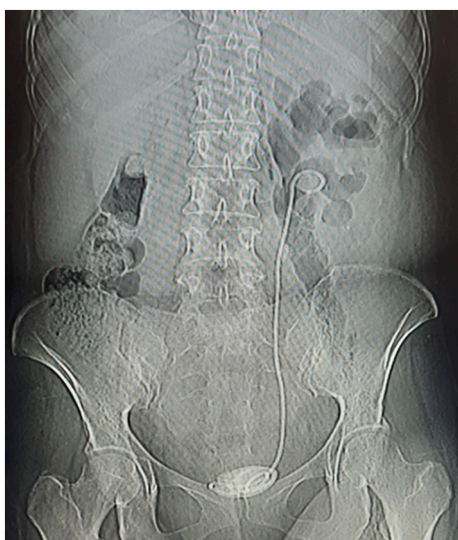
CT KUB scout image showing forgotten DJ stent with calculus at both ends and gas shadows in left renal area extending to psoas muscle area.
